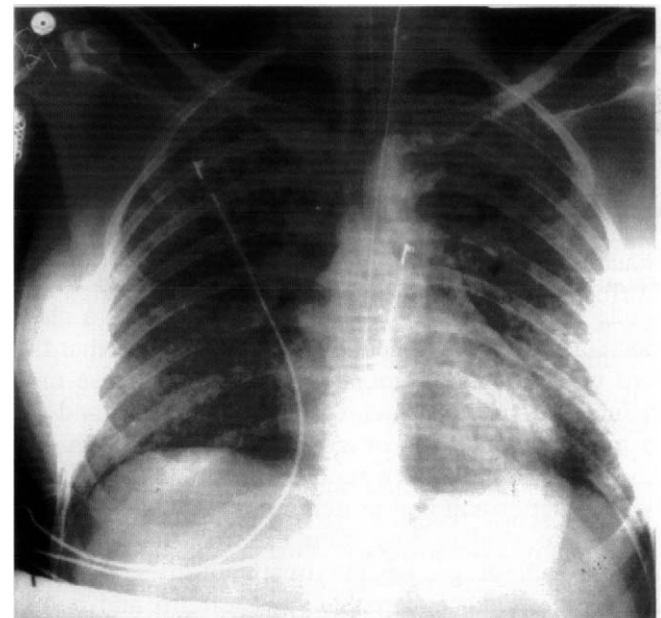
Chest radiograph following recurrence of pulmonary haemorrhage showing recurrence of diffuse infiltrates.
